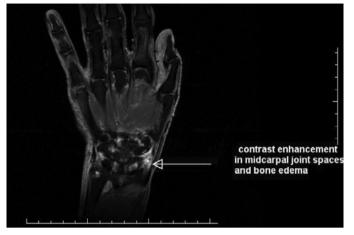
Coronal T1-weighted magnetic resonance image with contrast administration reveals synovitis at the wrist joint
